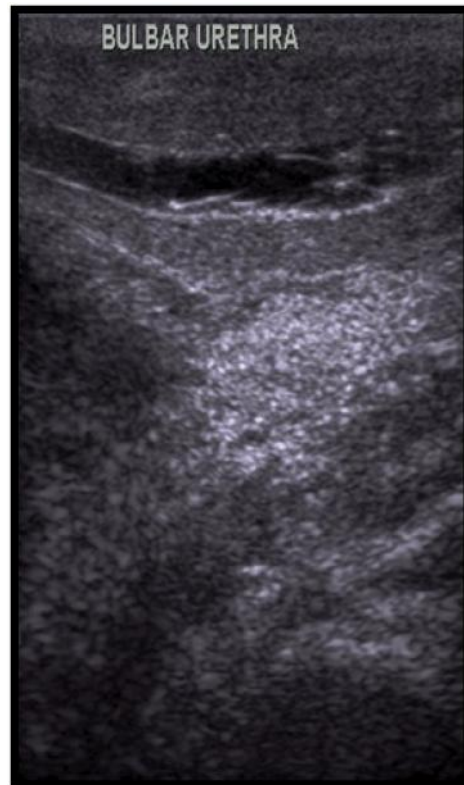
Sonographic imaging of bulbar urethral diverticulum.
